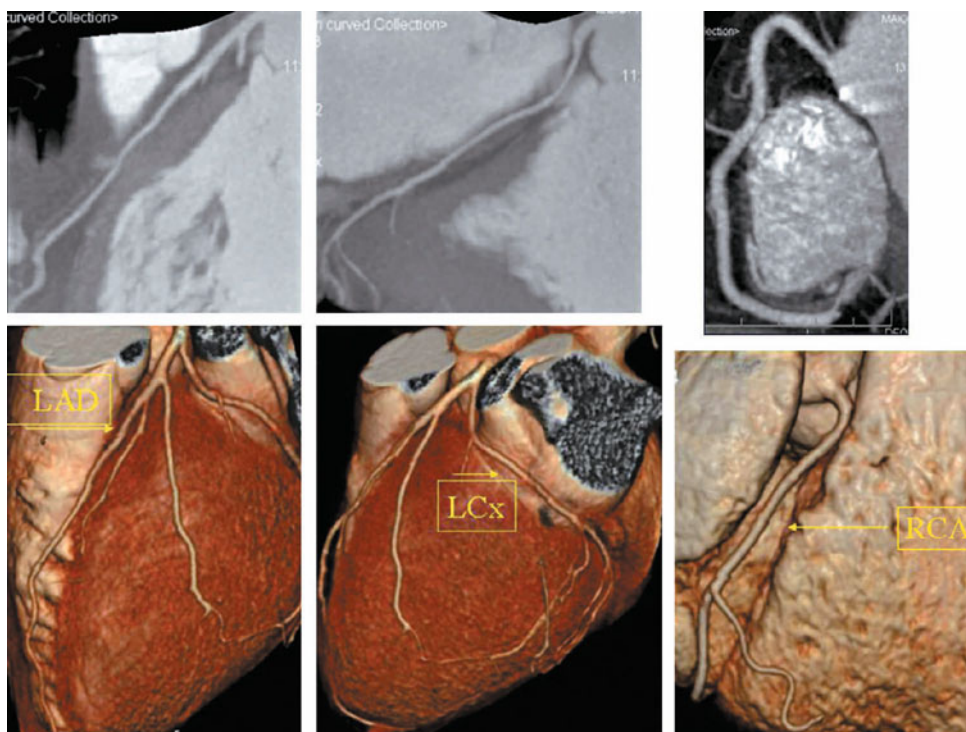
Evaluation of the coronary anatomy with multi-slice computed tomography. *RCA* Right coronary artery, *LAD* left anterior descending artery, *LCx* left circumflex artery
